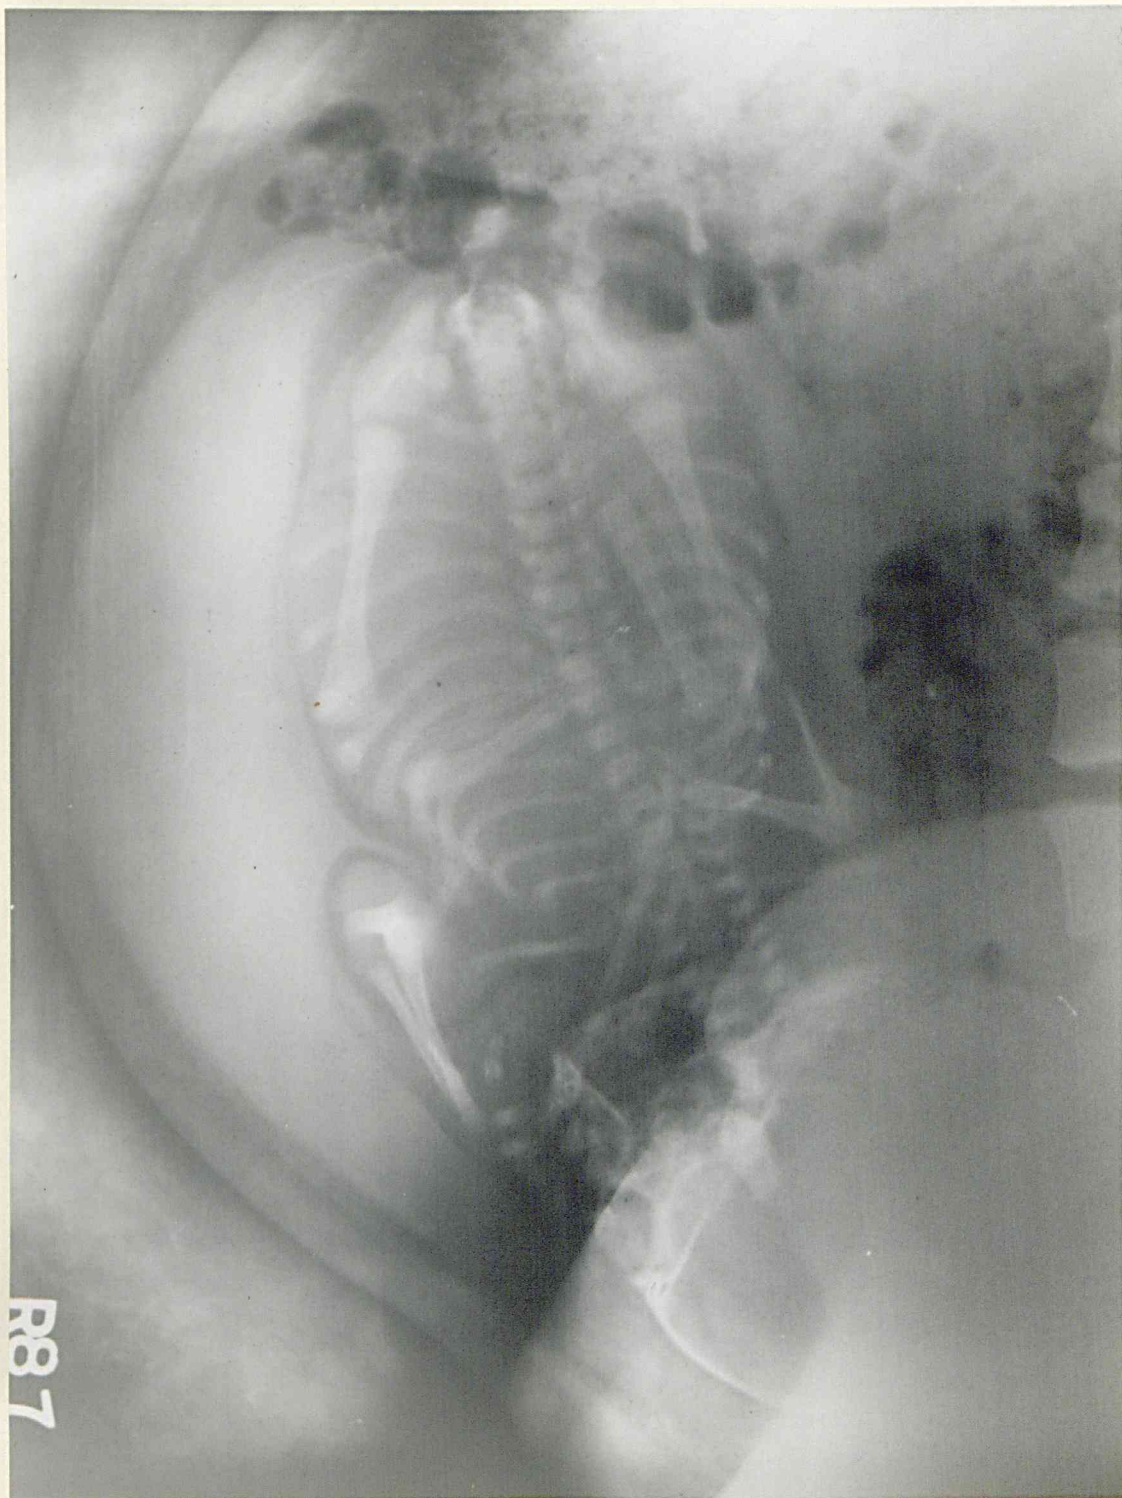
Soft tissue radiography - the lateral radiograph of the abdomen. Anterior implantation of the placenta in the upper uterine segment shown as a unilateral thickening of the soft tissue shadow of the uterus. (Case No. 72).
